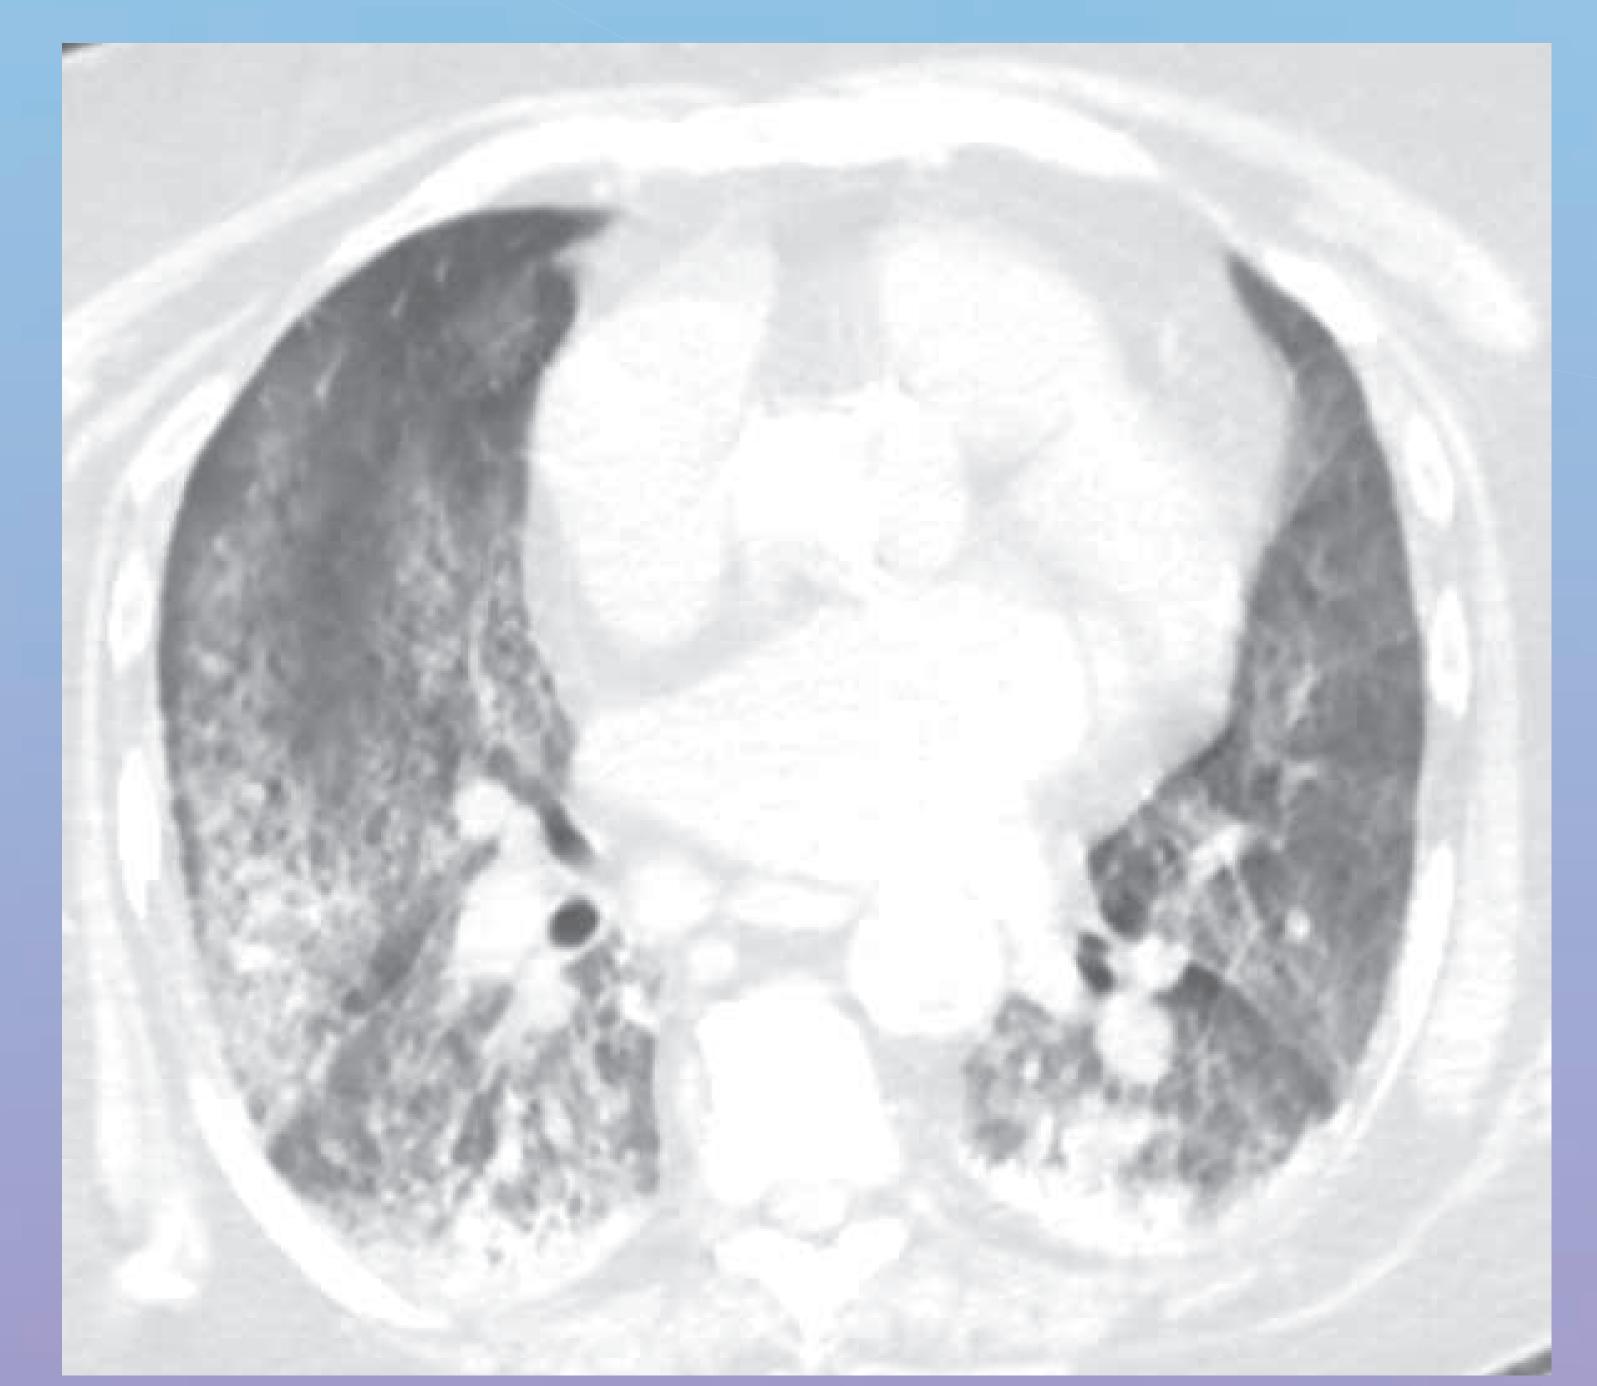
CT of the chest showing bilateral alveolar ground-glass opacities involving he upper lobes as well as the right middle and left lower lobes.
